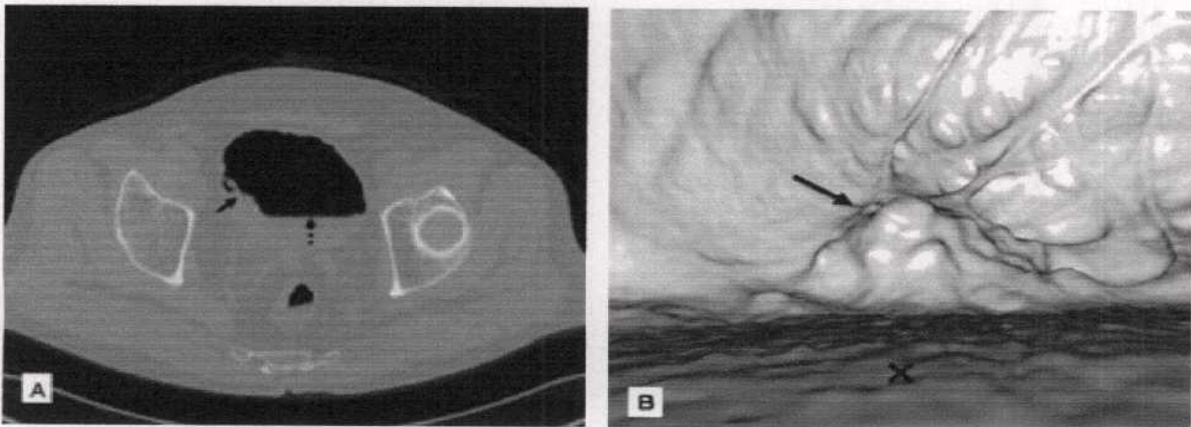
(A) Reconstructed two-dimensional CT (transverse image) from air VC. The bladder lumen is filled with air. A bladder tumour with a large radius is present on the right lateral bladder wall (arrow). The water surface appears at the base of the bladder (dotted arrow), and bladder tumour under the water surface cannot be detected. (B): Air VC images of a bladder tumour with a large radius (arrow). Trabeculations around the tumour are also well indicated, as is the water surface (asterisk). However, structures under the water surface cannot be detected. (Kawai et al., 2004).
